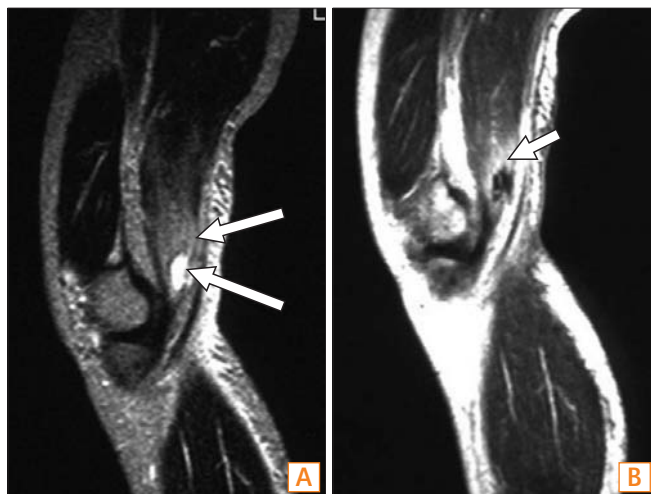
MRI findings in the patient's left lower leg. (A) Sagittal T2 weighted image with fat saturation shows a well-defined high signal intensity lesion (arrows) in the sartorius muscle with increased signal intensity of surrounding muscle. (B) Sagittal contrast enhanced T1 weighted image shows enhancement in surrounding muscle (arrow) without enhancement in the central lesion or with peripheral enhancement in the central lesion.
